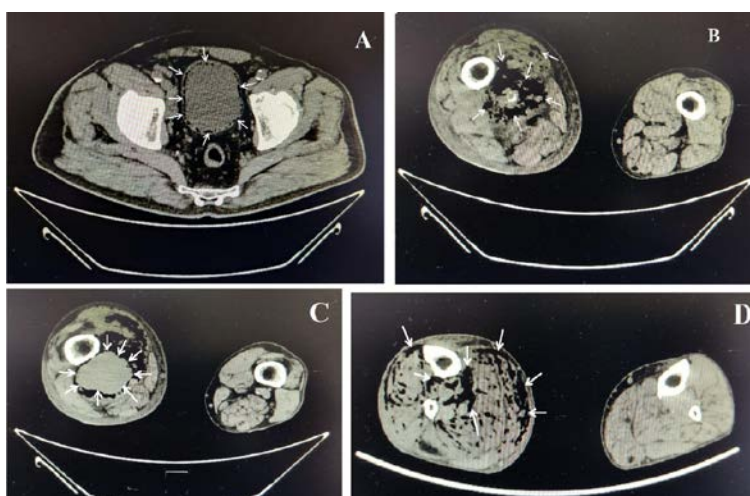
Pelvis and lower extremities computed tomography scan: A) Gas inclusions in urinary bladder wall (arrows); B) Gas inclusions in muscles of the right thigh; C) Right popliteal artery aneurysm (arrows) with gas inclusion around it; D) Gas inclusions in muscles of the right calf (arrows).
